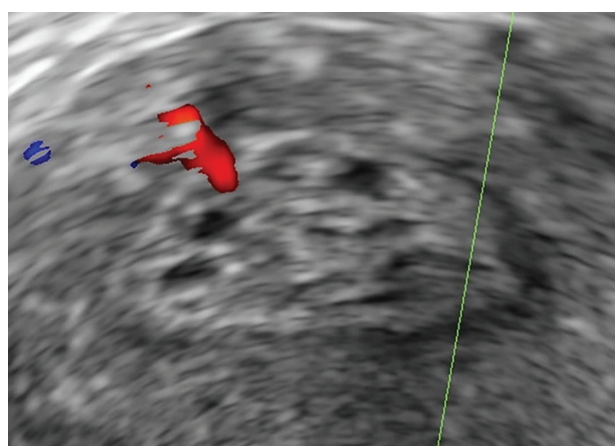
Doppler ultrasound: solid, isoechogenic, homogeneous endometrial polyp, with vascular pedicle and intermingled cystic areas. Favorable aspect for benignity.<sup>14</sup>
